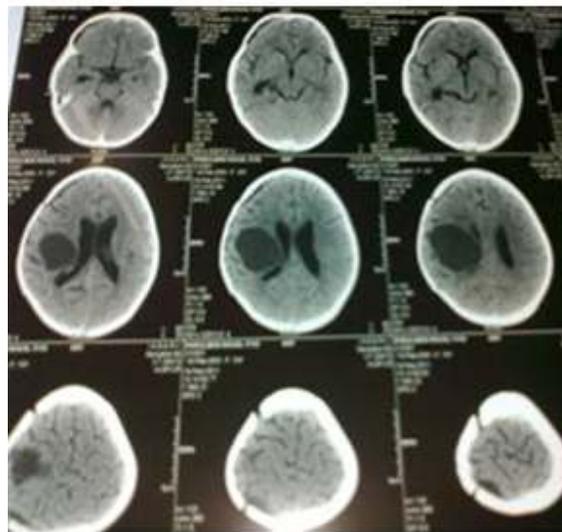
Transverse CT scan of brain showing cyst occupying the white matter of cerebrum
